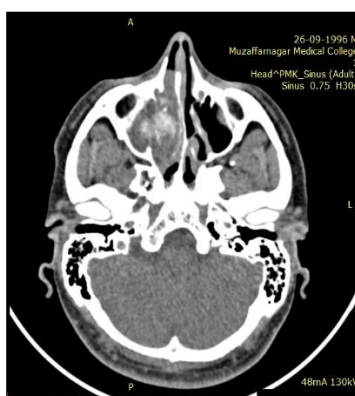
37-year-old male patient with complain of nasal obstruction with facial pain. Axial CT showing severe mucosal thickening in right maxillary sinus with soft tissue thickening extending into right nasal cavity showing hyperdense contents within it and associated bone remodeling, expansion of ostia and blocked right osteomeatal complex, suggestive of fungal polyposis with sinusitis.
